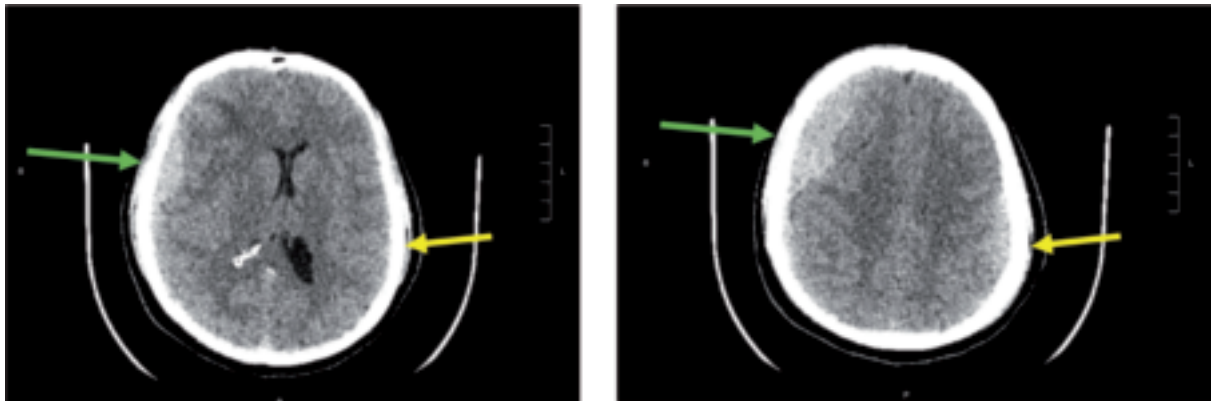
Encephalon computed tomography scan showing subdural hemorrhage in the right frontal-parietal region (green arrow), and a minimal hematic layer was present in the contralateral frontal-parietal region (yellow arrow).
